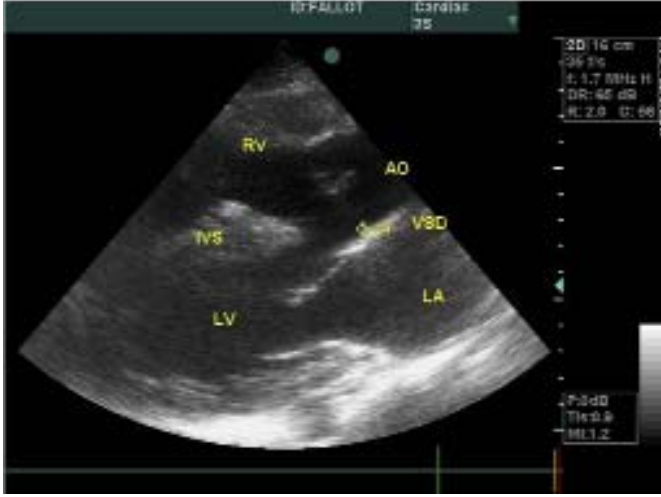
Echocardiographic findings of patient: Ventricular septal defect, overriding aorta, pulmonary artery atresia, and right ventricular hypertrophy.
